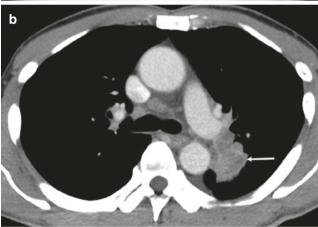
61-year-old man with left hilar mass. (a) Frontal radiograph shows convexity of aortopulmonary window (arrow). (b) CT demonstrates left hilar mass that was biopsy-proven to be a bronchogenic carcinoma
